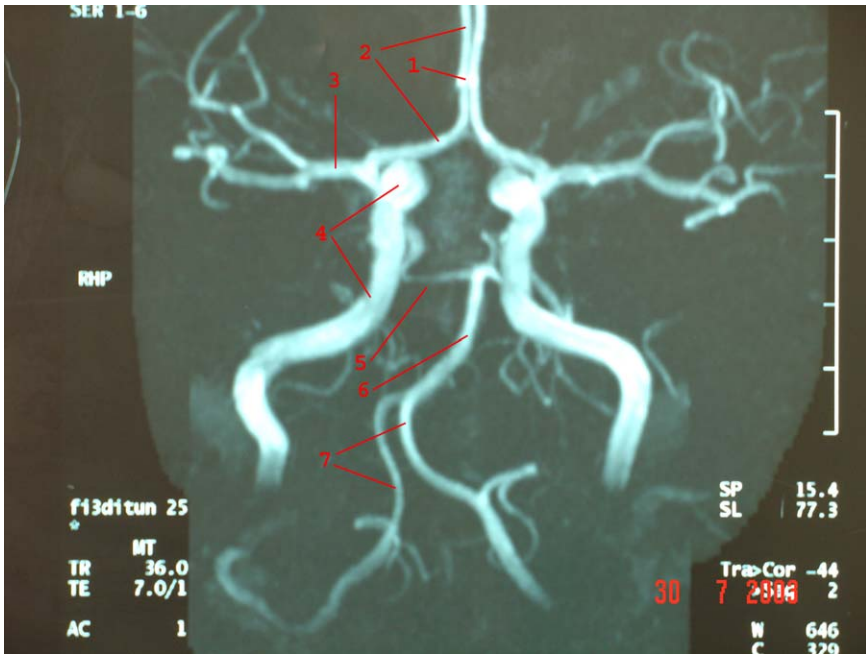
MRI scan of the circle of Willis. (1) Anterior communicating artery. (2) Anterior cerebral artery. (3) Middle cerebral artery. (4) Internal carotid artery. (5) Posterior communicating artery. (6) Basilar artery. (7) Vertebral arteries.
